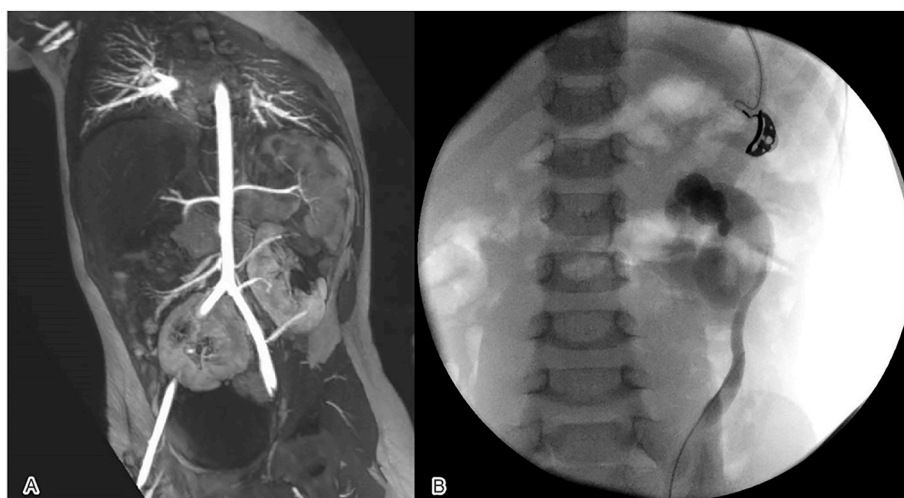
Radiological work-up: A. Abdominal angio-MRI. B. Retrograde pyelogram.
